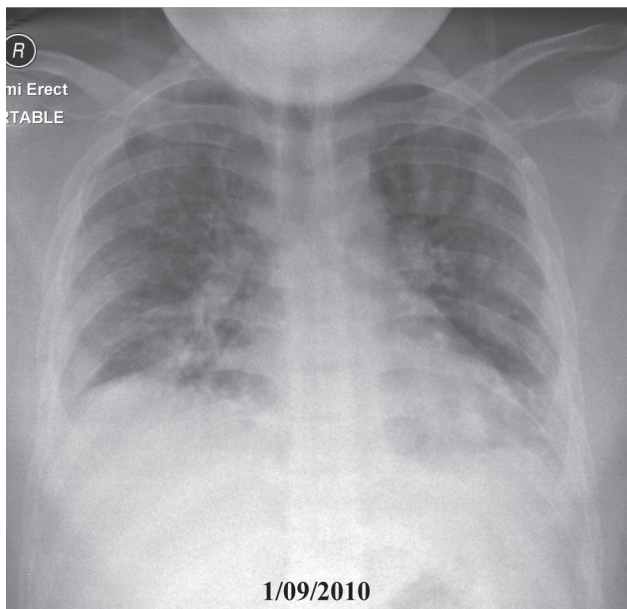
The chest x-ray reveals progressive diffuse pulmonary infiltration.
